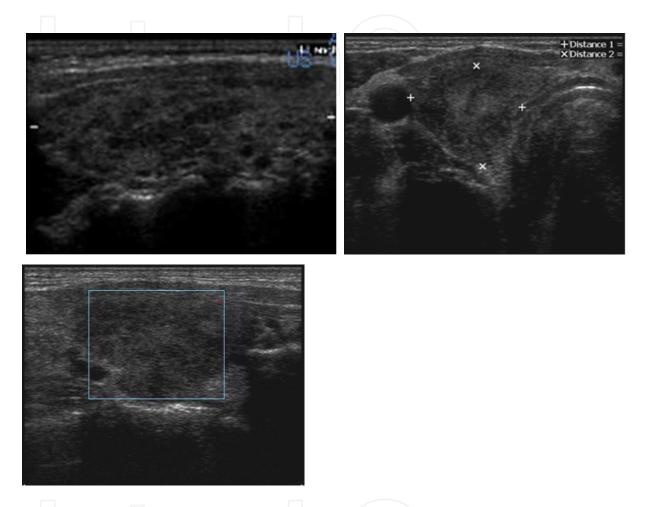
TUS image of subacute thyroiditis in the hyperthyroid phase (FT3: 10.7 pmol/l, FT4: 33.1 pmol/l, TSH: 0.039 mIU/l, antibodies negative). Note the low perfusion as shown by the Doppler imaging (right).
